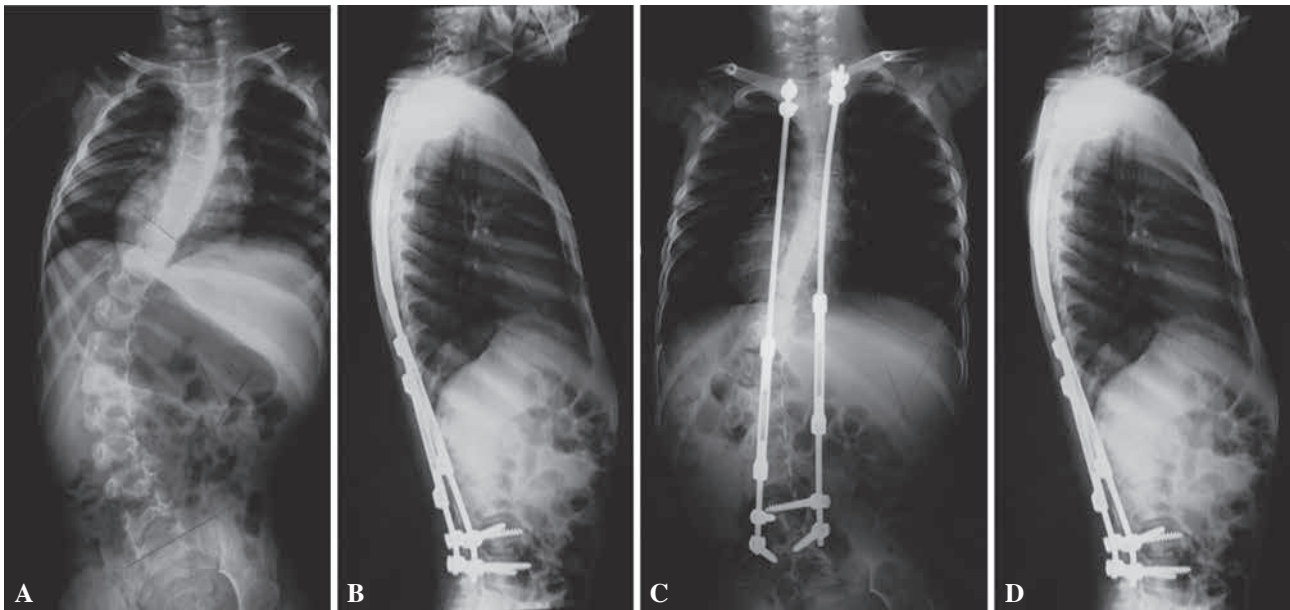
A, Preoperative AP radiograph of the spine of a 5-year old male with neuromuscular scoliosis demonstrating a 64-degree curve. He has been treated with serial casting for one year. B, Preoperative lateral radiograph demonstrating a 30 degree kyphosis and lordosis, respectively. C, Postoperative AP radiograph before the third lengthening of the dual growing rod instrumentation showing a 40 degree curve. D, Postoperative lateral radiograph showing acceptable maintenance of sagittal alignment.
